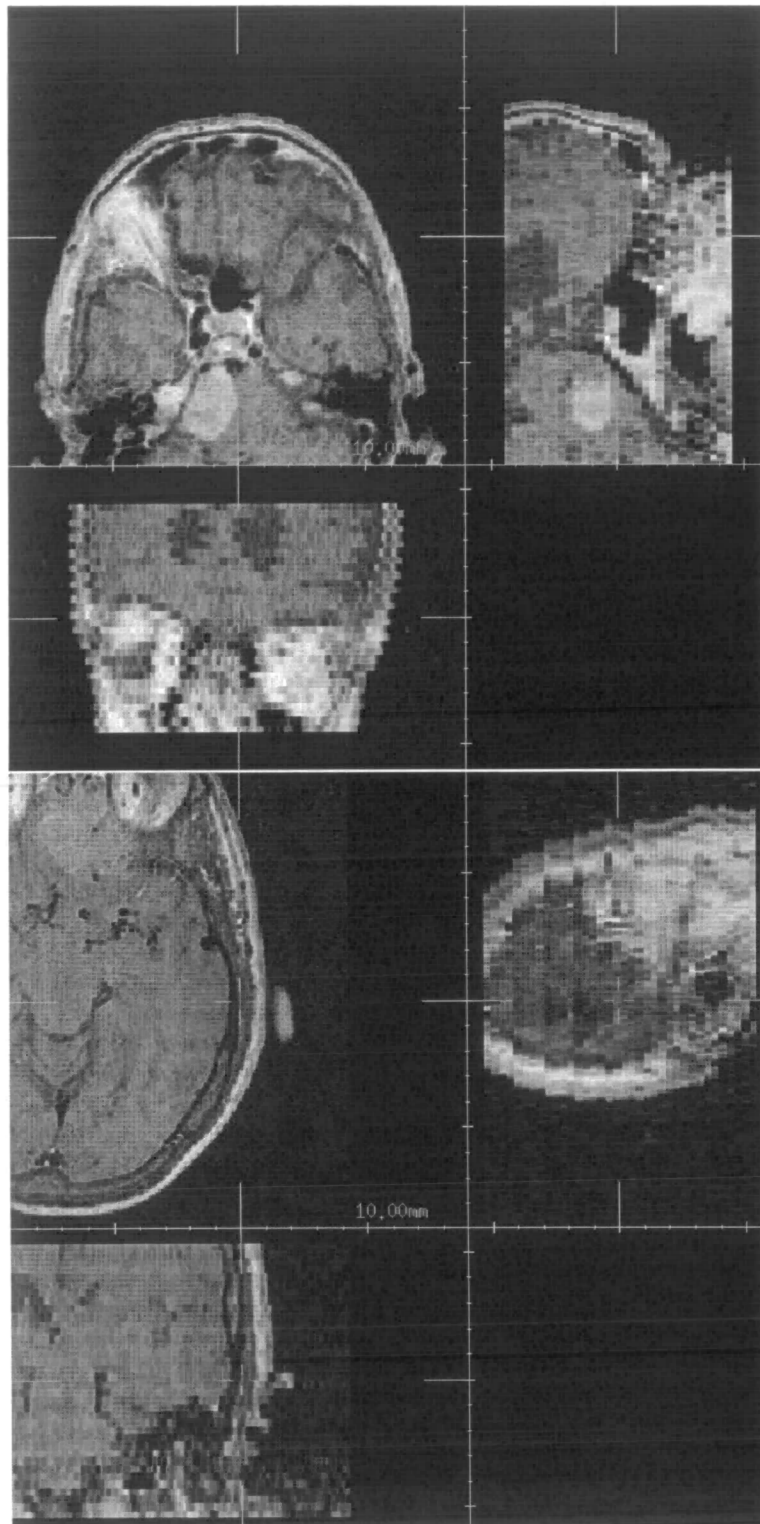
Example slices through the MR images of patient images B(lower) and D(upper) showing different artefact due to movement during 2D slice interleaved acquisitions.
